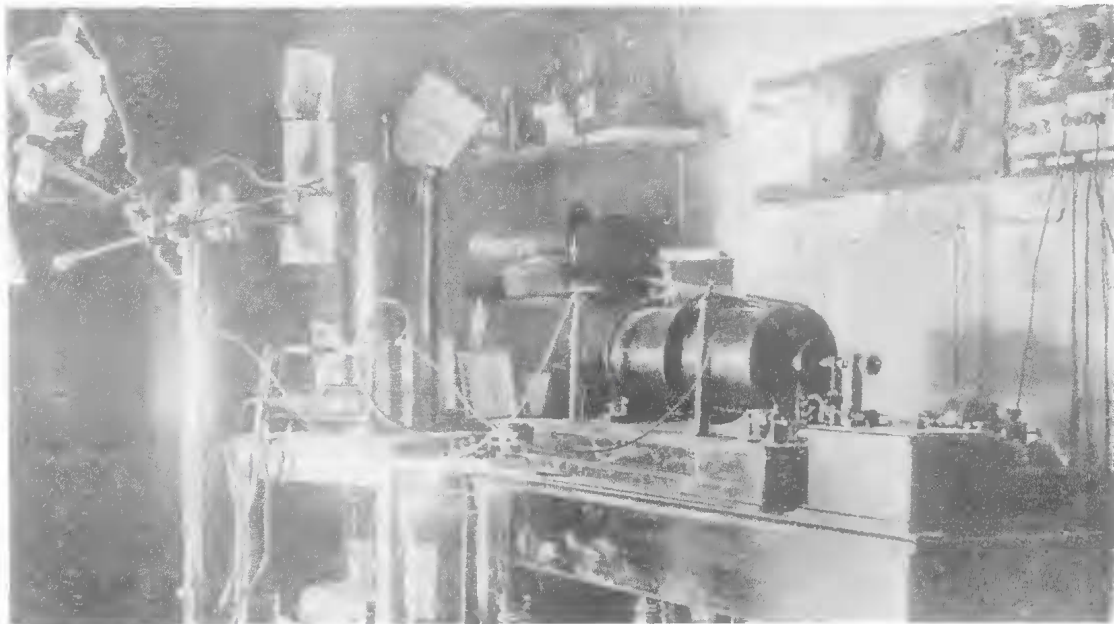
Dr Walter Nisbet's X-ray room in Townsville. His experience with X-rays began while serving in South Africa during the Boer War.
